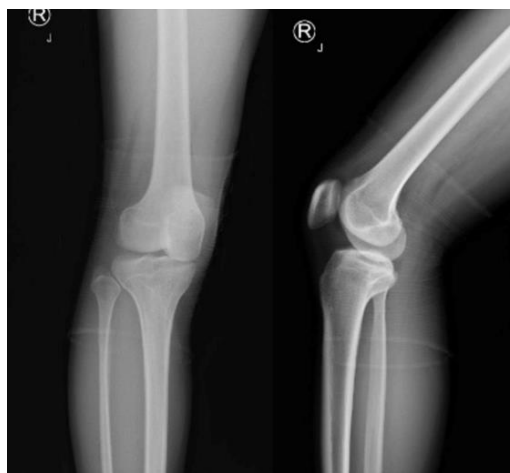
Anteroposterior and lateral standing x-ray of the right knee showed, widening of lateral joint space and increased concavity and subchondral sclerotic of the medial tibial plateau.
